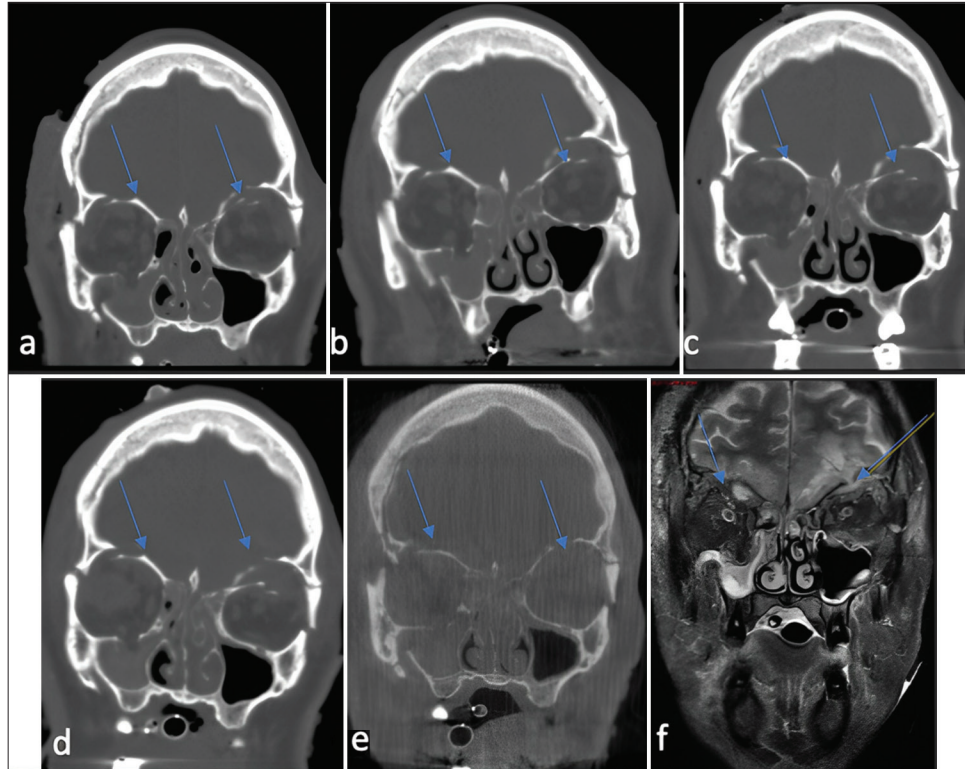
(a) Case 2: Computed tomography (CT) and Magnetic resonance imaging of fracture fragments over time. Coronal CT bone window image from admission showing inferior displacement of the right and left orbital roofs, now at 3.1 and 9.1 mm, respectively, and (b) 20 h later showing 2.8 and 13.2 mm of inferior displacement of the right and left orbital roof respectively. (c and d) The continued increase in depression over 2 days (e) led to repair and intraop O-arm image after reduction of fracture. (f) T2 coronal image with arrow denoting collagen onlay duraplasty. *Arrows denote findings described in each image.
